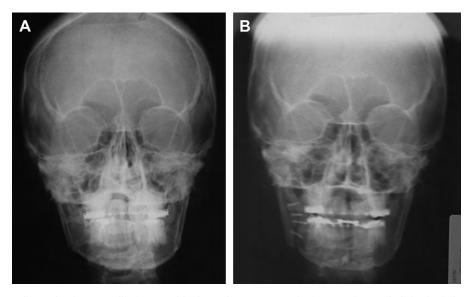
Radiographs show mandibular repositioning, advancement genioplasty, and a good skeletal relationship. No premolar extraction and good incisors inclination.
